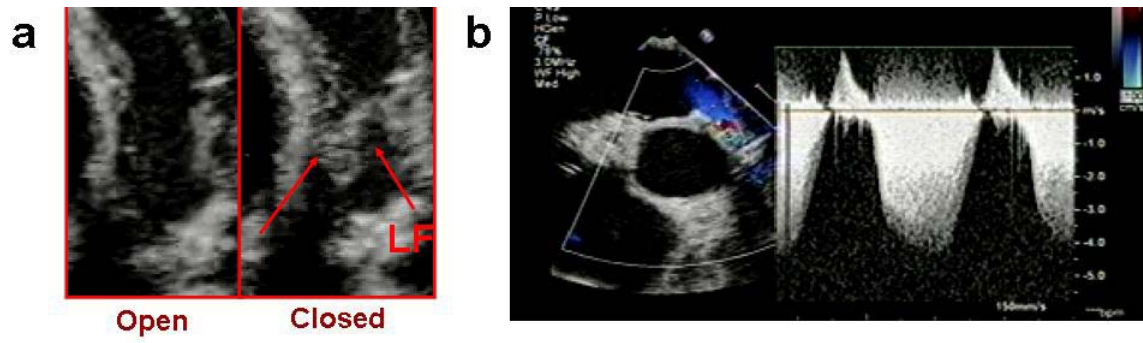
Echocardiogram images at 4.5 week of NAVT 7. a. valve leaflets in opened and closed position, b. Doppler flow profile
